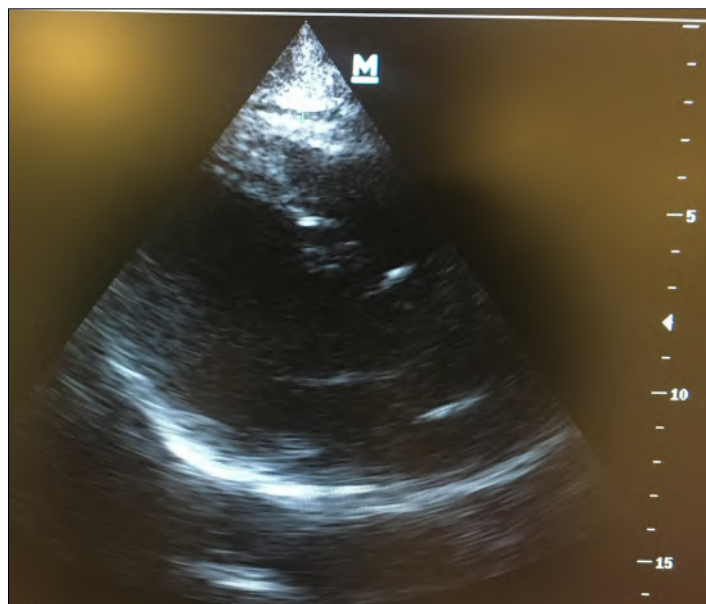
Measurement of epicardial fat tissue thickness by means of echocardiography.
